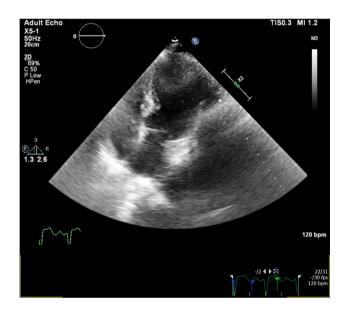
Transthoracic echocardiogram image from 2017 admission, consistent with Takotsubo cardiomyopathy
